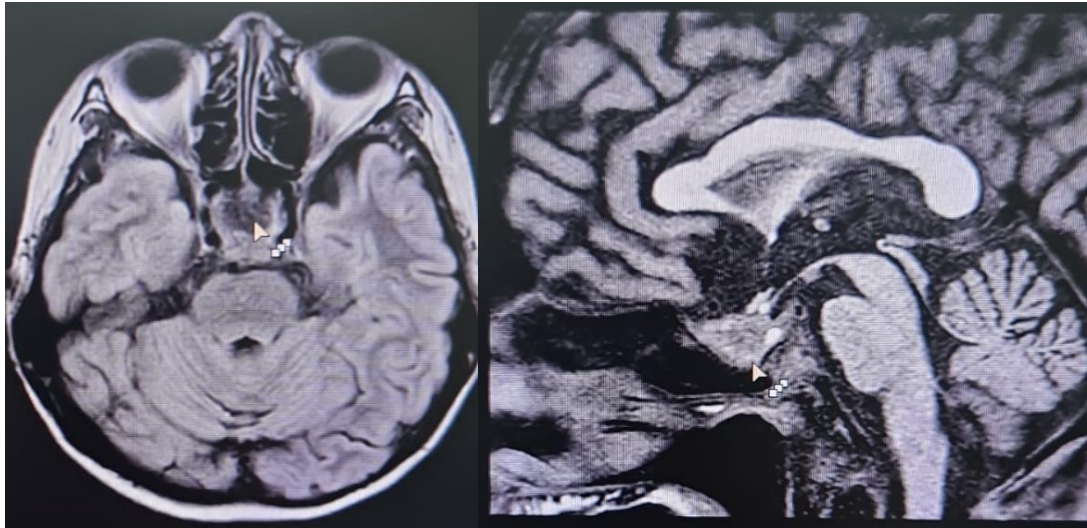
Pituitary MRI Result
